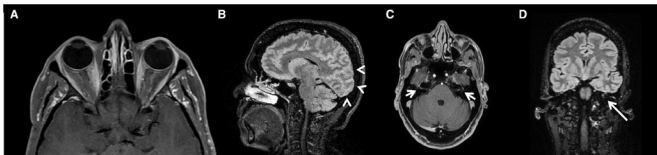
Neuroimaging. Brain and orbit MRI at the patient's admission showing discrete bilateral contrast enhancement of the perineural tissue surrounding the orbital segment of the optic nerve (A); hypertense FLAIR post-Gd signal of posterior supratentorial cortical sulcus (B, arrowheads); bilateral hyperintensity of the internal acoustic canal in the FLAIR post-Gd acquisition (C, short arrows). Subsequent brain MRI with increased signal intensity of the left cochlea on a FLAIR post-Gd sequence (D, arrow). FLAIR, fluid-attenuated inversion recovery; Gd, gadolinium.
